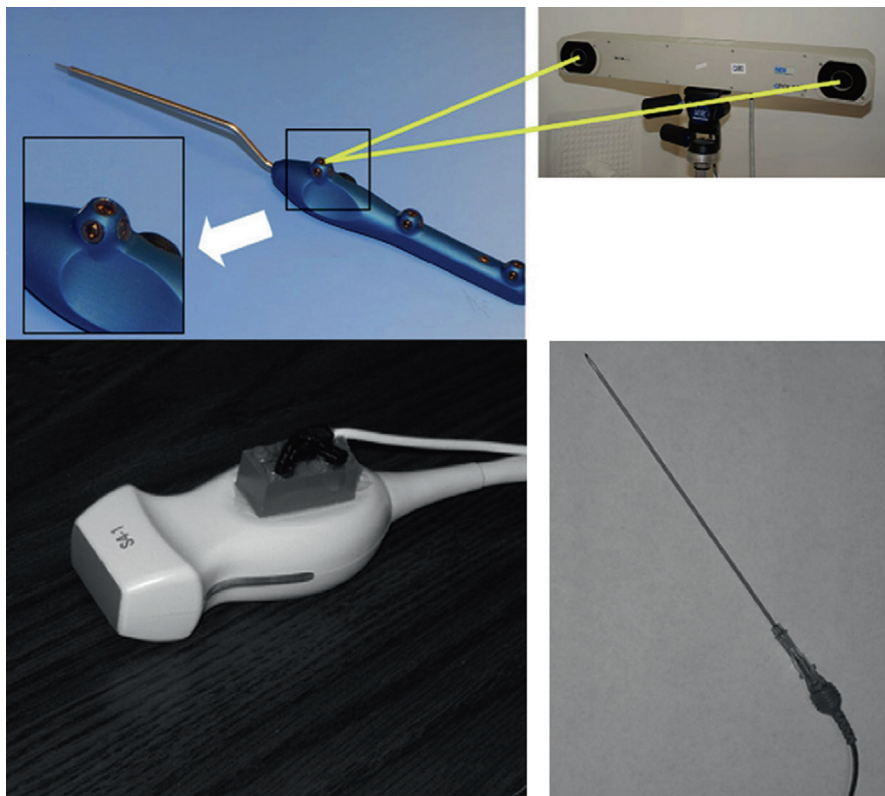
Examples of (*top*) optical and (*bottom, left, and right*) electromagnetic tracking systems. (*Top*) Both lenses of the camera (Polaris; Northern Digital) must view at least three infrared light-emitting diodes on the probe handle (area shown within *black box*) to determine the location of the probe tip. Reproduced with permission from Glossop (2009). (*Bottom, left and right*) Electromagnetic marker attached to (*bottom left*) an ultrasound imaging transducer, and to (*bottom right*) a stylet-sheath combination. Reproduced with permission from Krücker et al. (2007)
